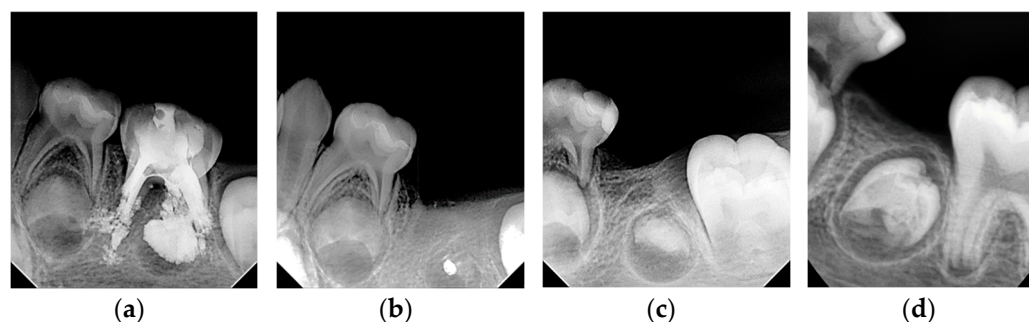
Periapical radiograph of left mandibular primary molar area: (a) initial visit; (b) two months after the extraction; (c) eleven months after the extraction; (d) three years after the extraction.
